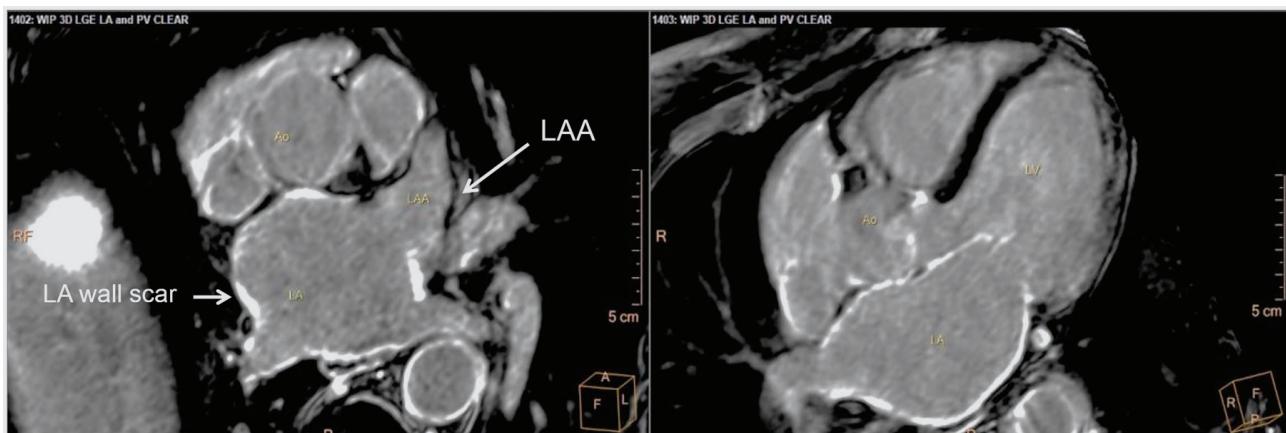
MRI-based imaging of atrial wall fibrosis. MRI cross section at the level of the left atrium (left side) and 5-chamber view (right side). Atrial fibrosis can be detected in various regions of the atrial wall (white spots). Only the left atrial appendage (LAA) is largely free of scar.
